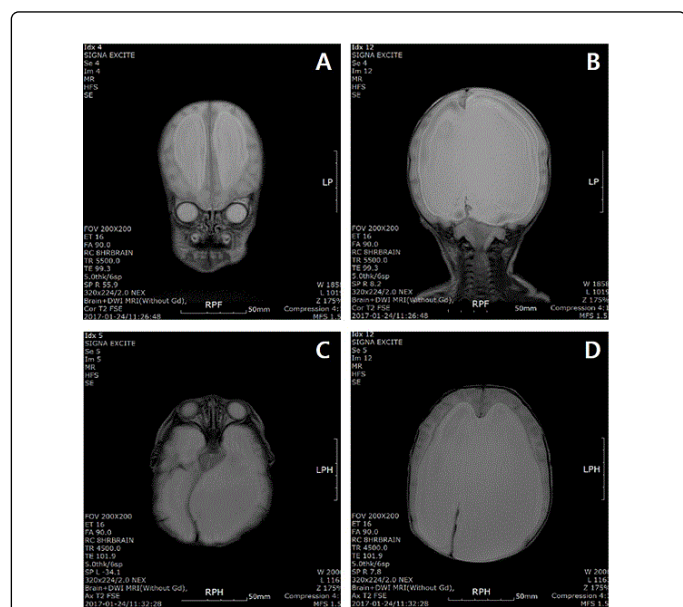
Brain MRI showing the dilation of both the lateral and 3rd ventricles and the agenesis of the septum pellucidum and the corpus callosum. A and B: Coronal view, C and D: Transverse view.
